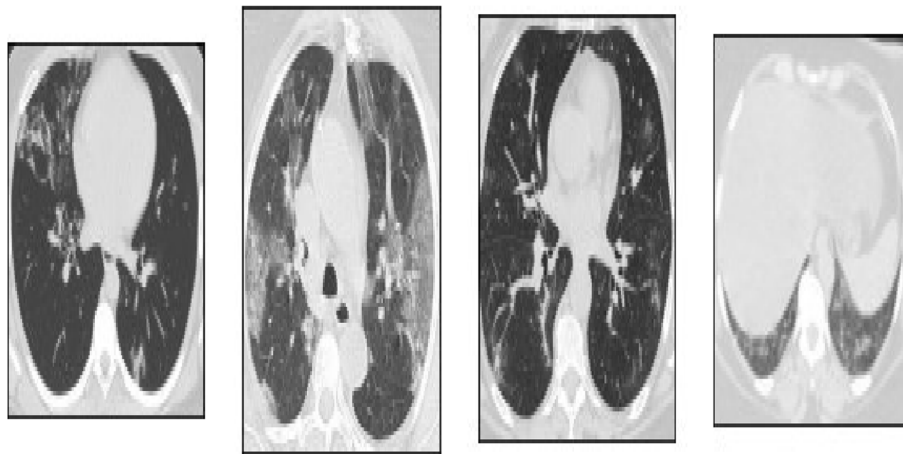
COVID-19 Disease Images of CT-Scan
